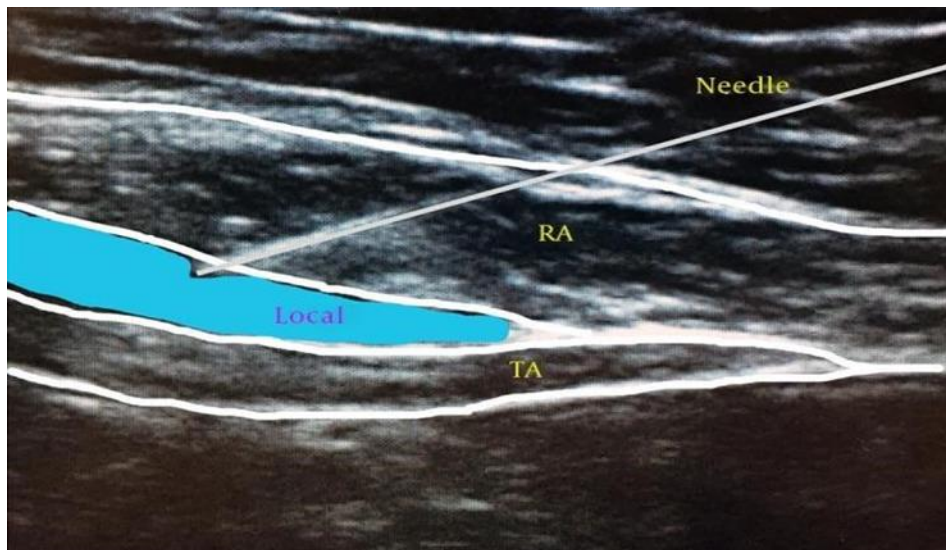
Ultrasound Image of Needle Insertion and Local Injection TA, transverse abdominis muscle; RA, rectus abdominis muscle. The needle is inserted in the fascial plane between the TA muscle and RA muscle. As shown in this image, local anesthetic injection should cause separation of TA and RA muscles. The injection is medial to the semilunaris in this image (40).
